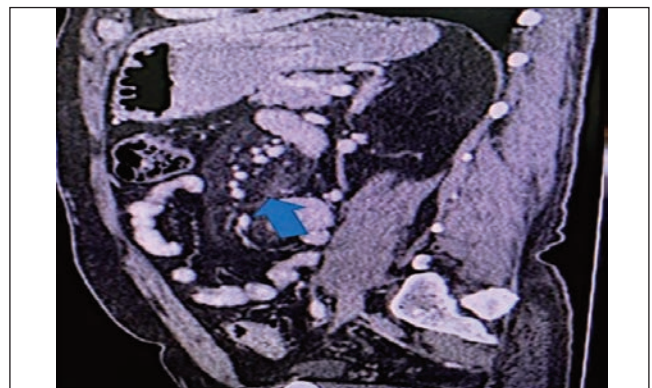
CT scan of the abdomen with contrast sagittal view of Case no. 4 showing significant fat stranding within the mesentery in the mid and left side of the abdomen with few sub-centimetre lymph nodes.
